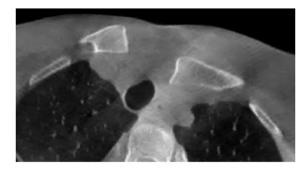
Axial CT scan from O-arm scan after attempted closed reduction, demonstrating unsuccessful closed reduction attempt. *CT*, computed tomography.
